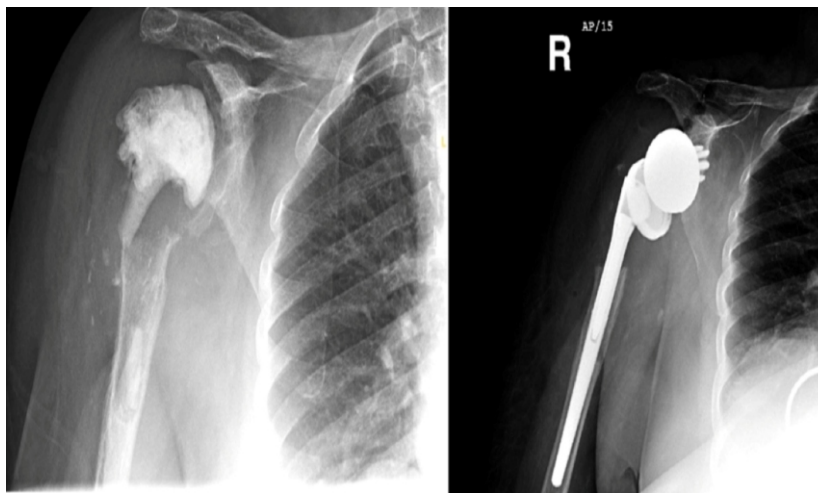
Anteroposterior radiographs of the right shoulder. 2 months post antibiotic spacer placement, demonstrating fracture through the humeral stem of the antibiotic spacer (left). Subsequently, the patient underwent successful removal of the antibiotic spacer and re-implantation of reverse total shoulder arthroplasty components in September 2020 (right).
